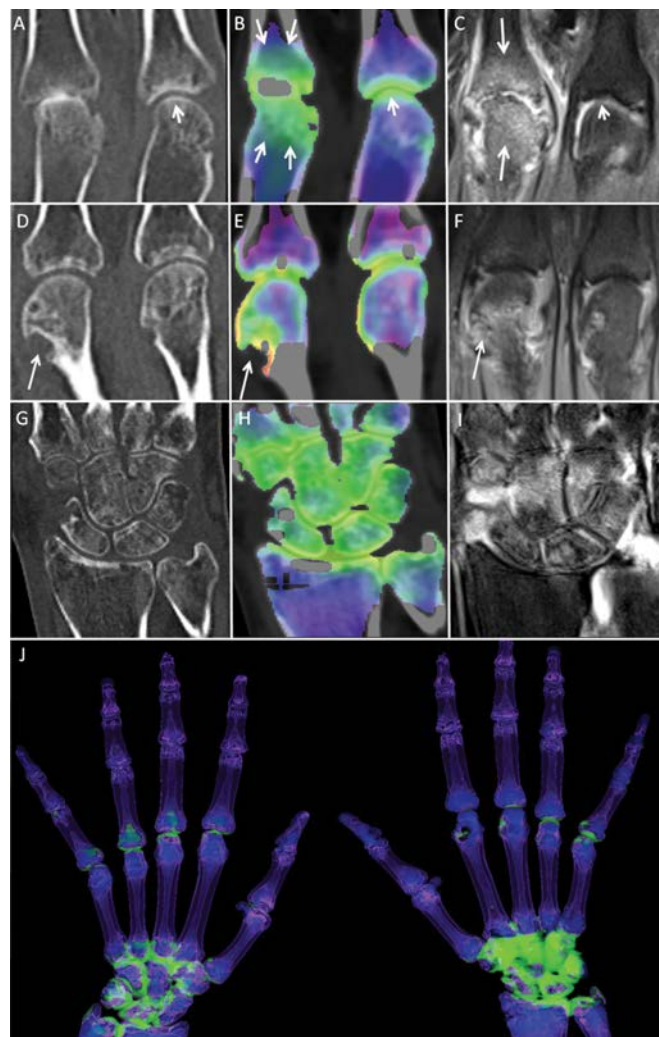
(A, B) Conventional and colour-coded DECT images from the same scan and (C) T2FS MRI of the second and third MCP joint in a 39-year-old woman with RA. MCP2 is normal with a smooth outline of cartilage and bone plate (short arrows) on the colour-coded maps and on MRI. BME of the bones of the MCP3 joint is seen as extensive and ill-defined green colour on the DECT image (arrows) and corresponds to BME on the MR image (long arrows). (D, E) Conventional and colour-coded DECT images and (F) T2FS MRI in a 43-year-old woman with RA showing BME (arrow) surrounding a large pocket erosion of head of the second metacarpal. (G, H) Conventional and colour-coded DECT and (I) T2FS MRI of the wrist showing extensive BME of the wrist in a 46-year-old woman with RA. (J) 3D DECT colour-coded images showing BME of the right carpal bones only. (B, E, H) The ability of DECT to detect BME in sclerotic areas (grey spots) is limited. BME, bone marrow oedema; BMEL, bone marrow oedema lesion; DECT, dual-energy CT; MCP, metacarpophalangeal joint; RA, rheumatoid arthritis; T2FS, T2-weighted fat saturated.
